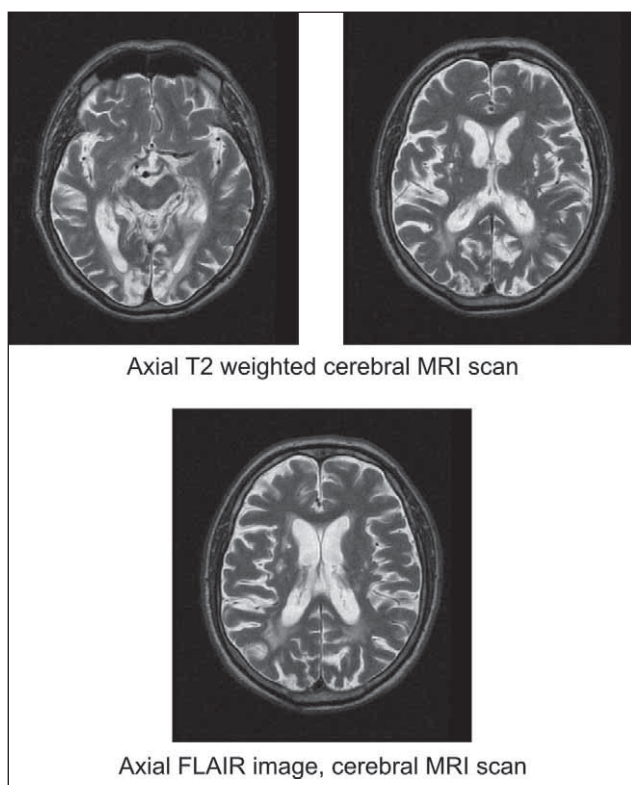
Patient M.G., 71 years, known with arterial hypertension, dyslipidemia, history of 2 bilateral PCA Infarcts (first one in 2004 and the second in 2008), cortical blindness, with sphincter abnormalities for some months, gait and memory difficulties aggravated. Cerebral MRI scan shows: mixed brain atrophy, leukoaraiosis stage II-III, bilateral old occipital ischemic lesions.
